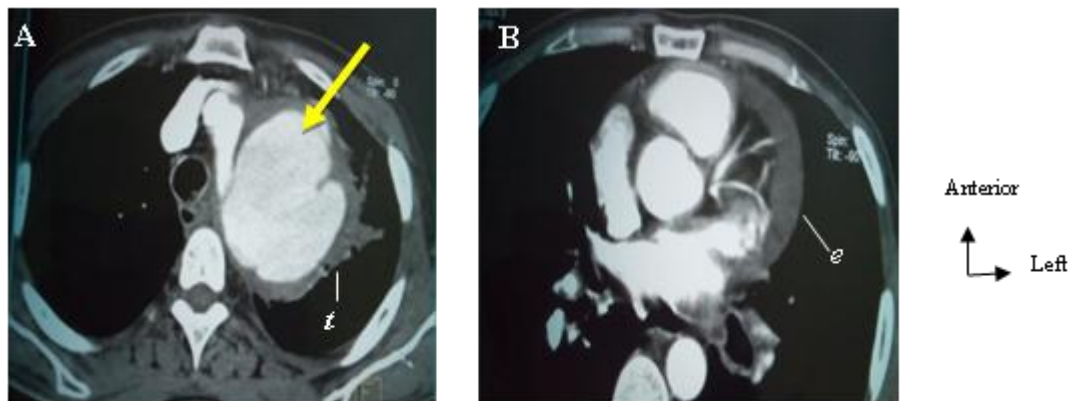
CT angiography, axial sections showing a sacciform aneurysm of the aortic arch (arrow) with wall thrombosis (t) (A) and a pericardial effusion (e) (B)
